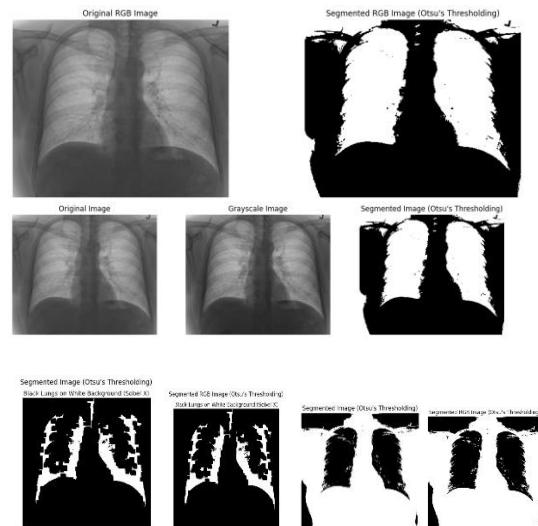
Chest X-Ray Image Segmentation with Canny, Sobel, and Felzenszwalb
